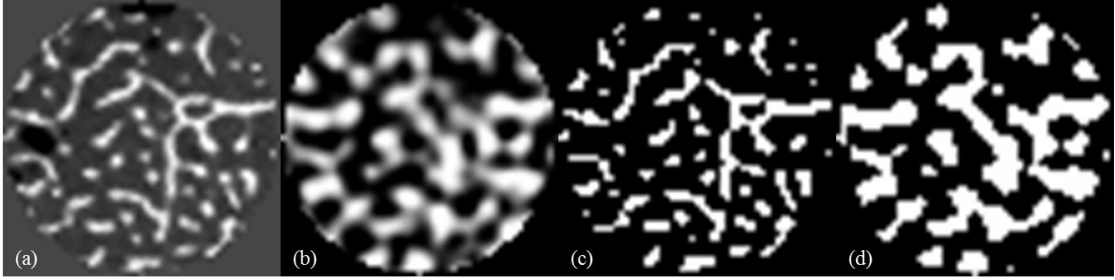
Transverse view of one matching slice of trabecular bone using the same cylindrical VOI. (a) Fuzzy image of μ -CT. (b) Fuzzy image of MDCT. (c) Binary image of μ -CT. (d) Binary image of MDCT.
